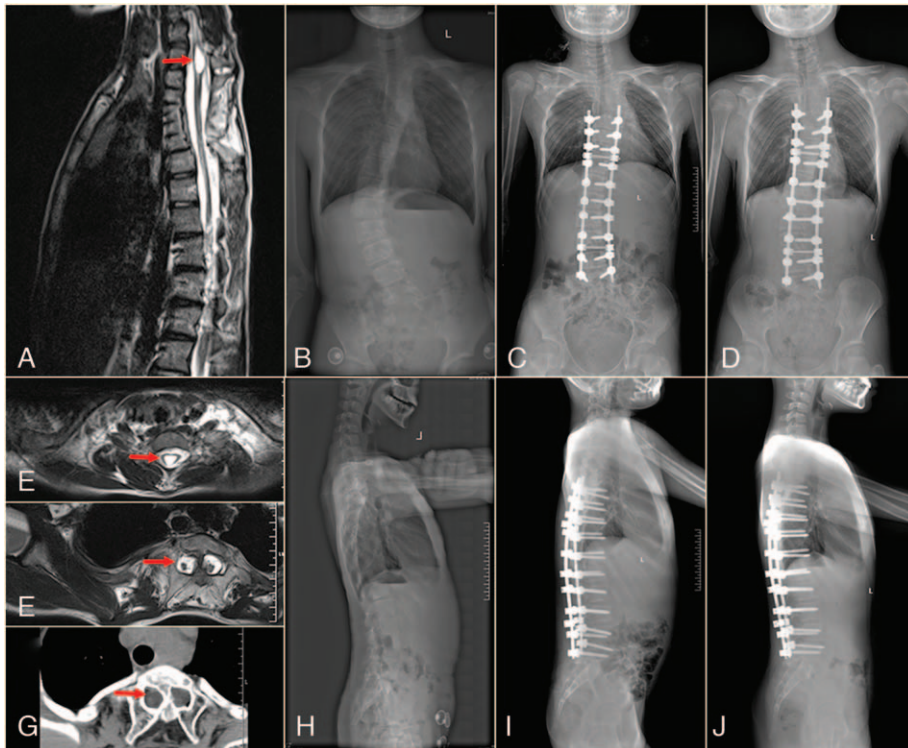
A 11-year-old girl with congenital scoliosis and 2 intraspinal anomalies (coexisting syringomyelia and type 1 split cord malformation [SCM]) received posterior correction and instrumentation without preliminary neurosurgical intervention. No neurologic deficits were found before or after surgery. (A) A syringomyelia on sagittal magnetic resonance imaging. (E,F) Syringomyelia and type 1 SCM on axial magnetic resonance imaging. (G) A consecutive osseous spur on axial CT imaging. Preoperative anteroposterior (B) and lateral (H) views. Postoperative anteroposterior (C) and lateral (I) views. Final follow-up anteroposterior (D) and lateral (J) views.
